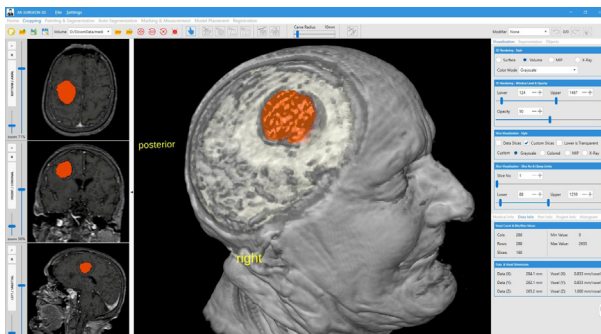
3D image of preoperative MR and CT images of a right frontal mass patient segmented on the Illumetry XR screen integrated with the ArSurgeon software developed by SimBT
